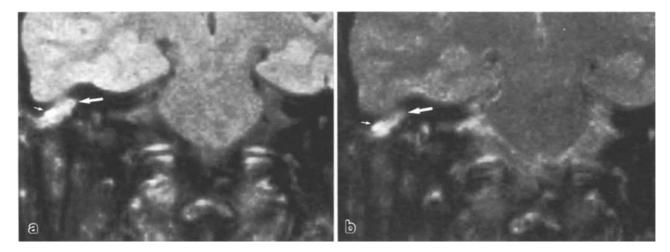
Coronal T2-weighted, (SE a 1700/60; b 1700/120) 4 mm thick, MR image: the mass exhibits a signal similar to that of the adjacent brain (*arrow*), underlined by a small hyperintense area (*short arrow*)
